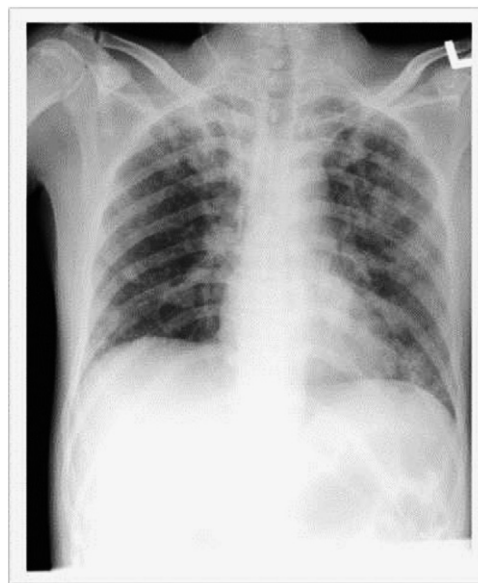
Chest X-ray on 10th day of admission.
